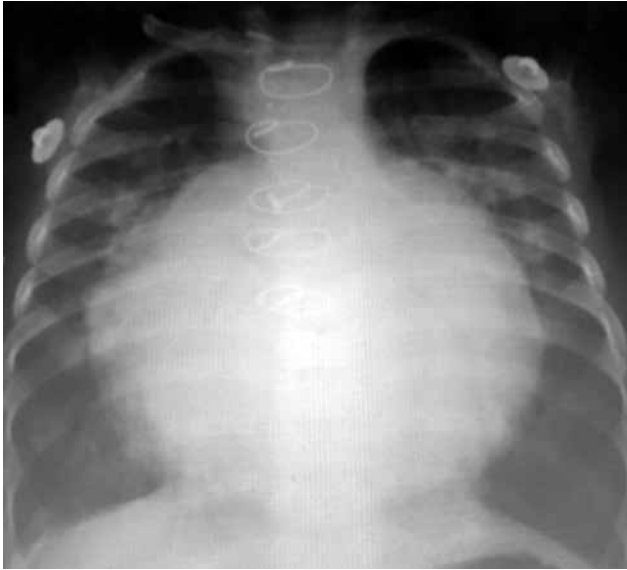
Chest X-ray showing significant cardiomegaly.
